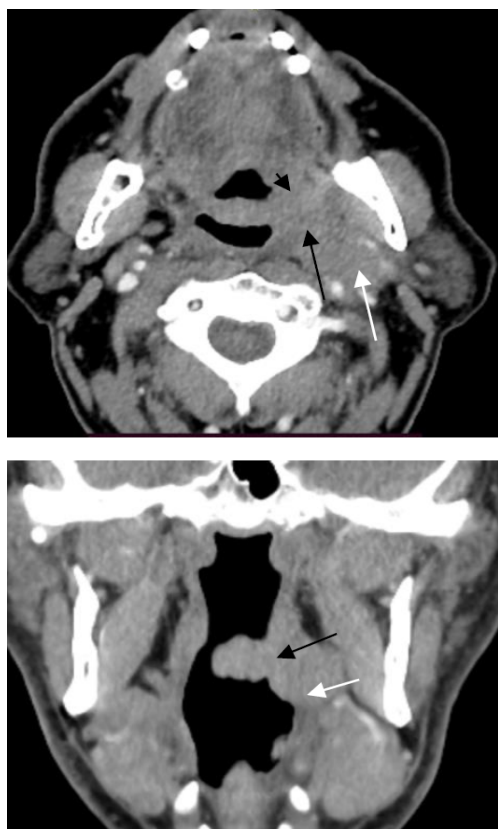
Squamous cell carcinoma of the left anterior tonsillar pillar a. axial CT image demonstrates the enlargement of the left anterior tonsillar pillar (small black arrow) and an enhancing mass into the tonsillar fossa with the parapharyngeal space invasion (large black arrow); b. coronal CT image shows the left anterior tonsillar pillar tumor a level II adenopathy with the encasement of the left internal carotid artery (large white arrow)
